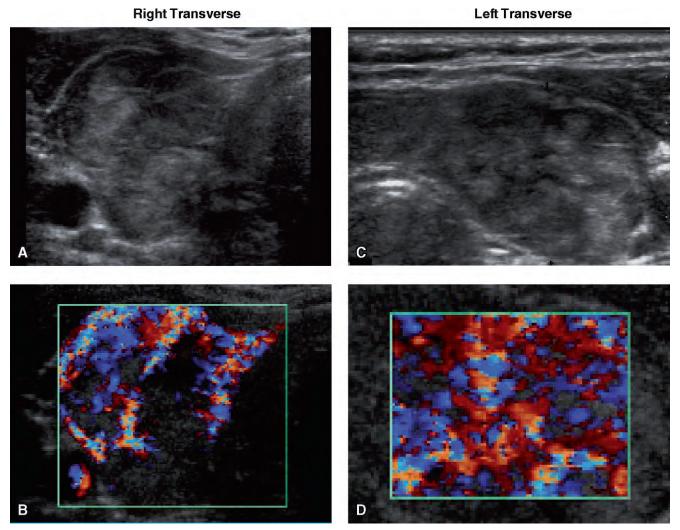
Ultrasound of hyperplastic nodules in both lobes. A, Right Transverse. B, Color Doppler, right Transverse. C, Left Transverse. D, Color Doppler, left Transverse.
